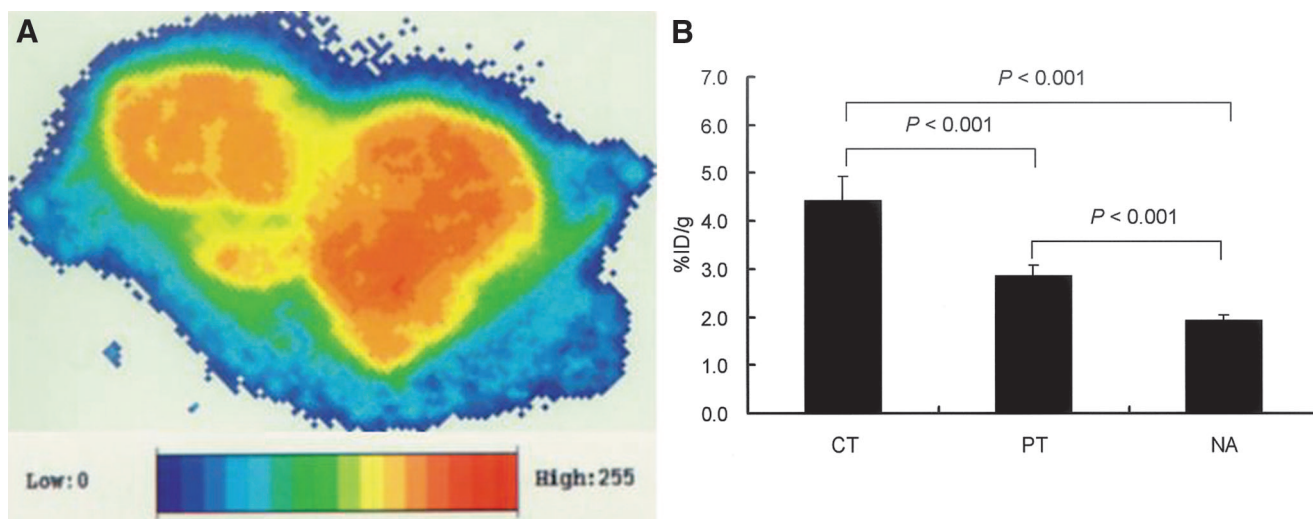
shows the representative autoradiogram of  $^{18}\text{F}$ -FDG distribution in the tumor. The ARG images showed heterogeneous  $^{18}\text{F}$ -FDG distribution with a relatively higher  $^{18}\text{F}$ -FDG accumulation level in the CT regions of viable tumor tissues.
